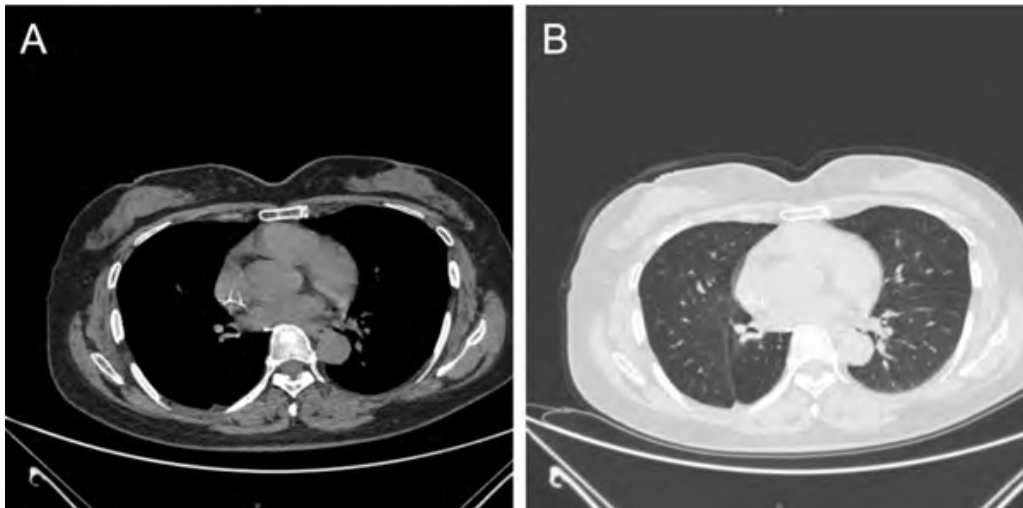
A 3-month postoperative follow-up chest CT.
